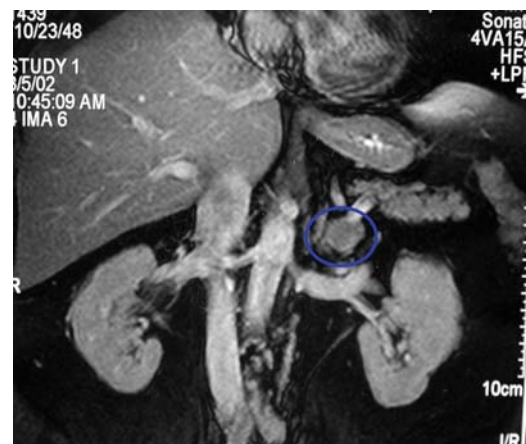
An MRI demonstrates a left aldosterone-producing adrenocortical adenoma.
